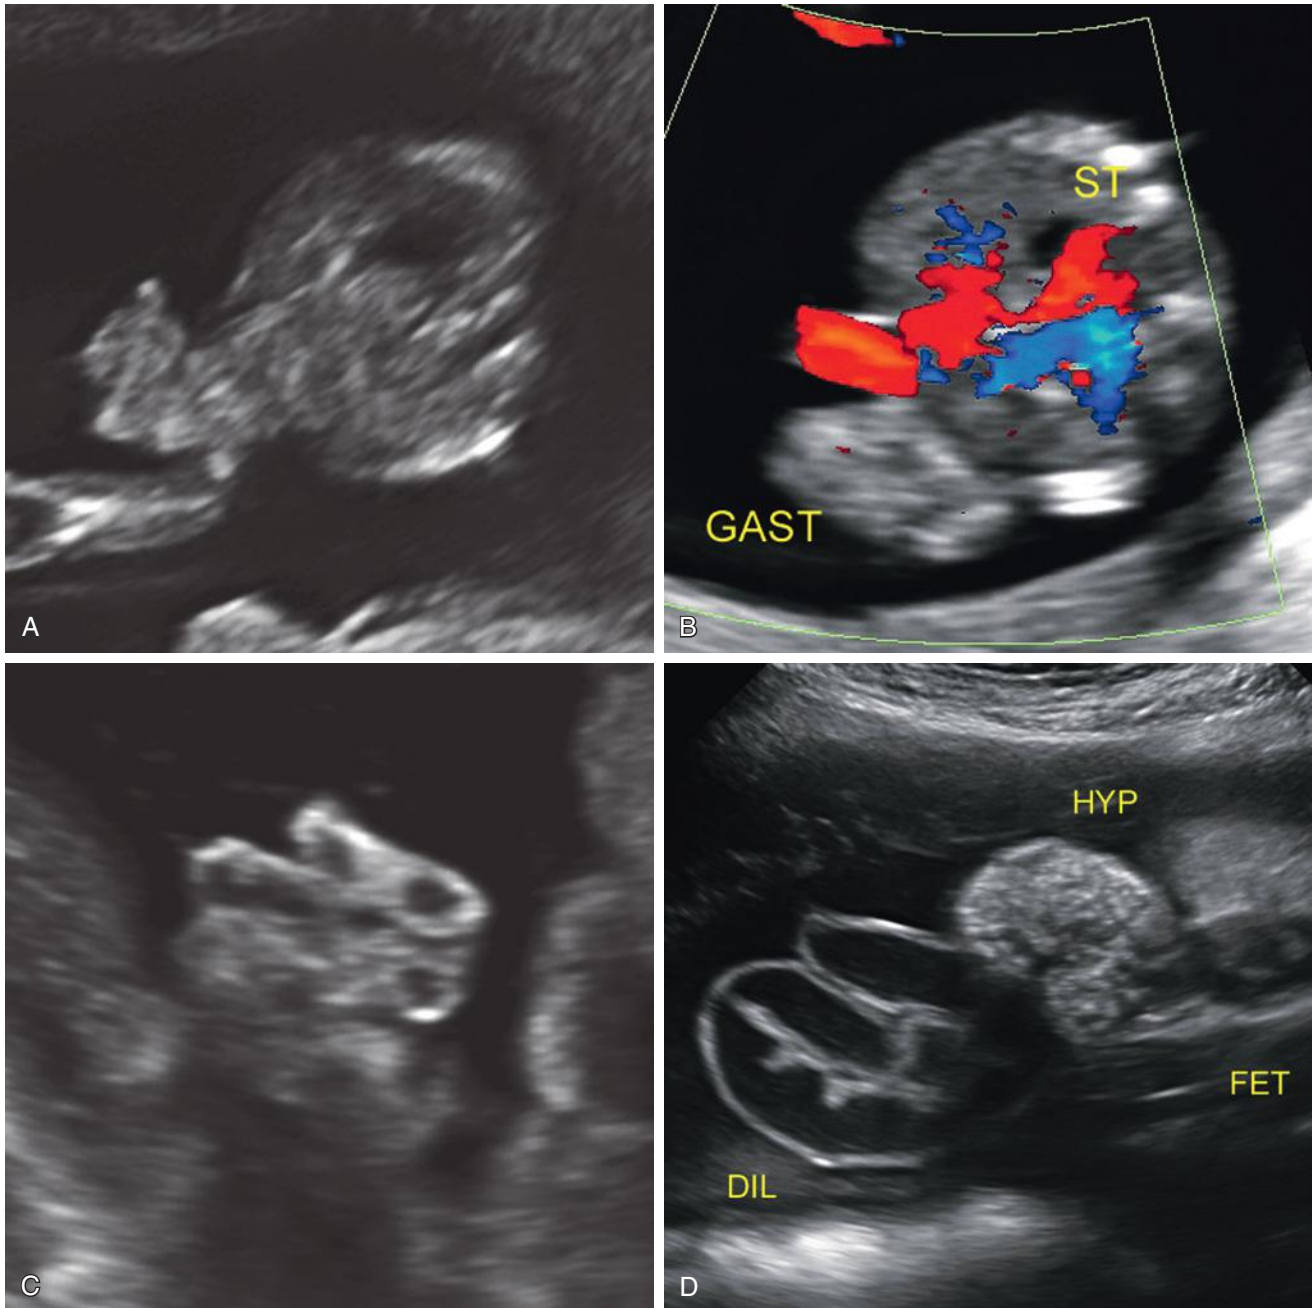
Gastroschisis. A, At 13 weeks, externalized segments of free-floating bowel are seen, suggesting gastroschisis rather than omphalocele. B, Color Doppler sonography demonstrates flow within the umbilical cord. The abdominal wall defect is right paramedian, adjacent to the cord insertion, typical of gastroschisis. ST, stomach; GAST, gastroschisis. C, Free loops of externalized nondilated bowel, surrounded by amniotic fluid, are more easily demonstrated at 22 weeks. D, In the third trimester, this fetus (FET) developed dilated loops of extra-abdominal intestine (DIL) and a hyperechoic segment (HYP), presumably from inspissated meconium within colon. These findings did not alter obstetric management. The infant weighing 1.7 kg (<1st percentile) was delivered at 37 weeks. The gastroschisis was reduced using a silo, the fascial defect was closed on day 11, and the child was discharged on day of life 55.
